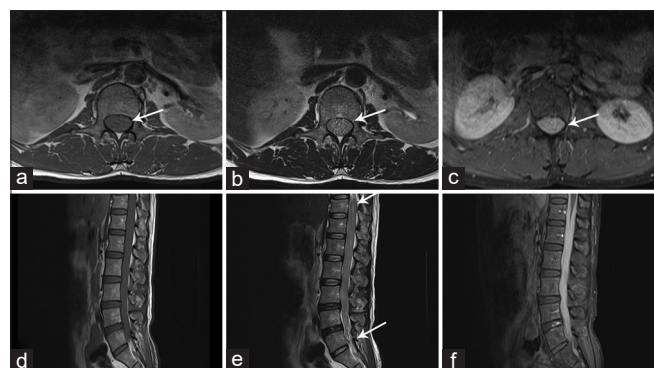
(a) Preoperative magnetic resonance imaging precontrast T1 axial, (b) T2 axial, (c) T1 postcontrast axial images, (d) Precontrast T1 sagittal, (e) T2 sagittal, (f) T1 postcontrast sagittal images. Nerve roots in the cauda equina show diffuse thickening with obliteration of intervening cerebrospinal fluid signal in T2-weighted images which appears isointense on T1-weighted image. Diffuse homogenous enhancement noted within the theca encircling the distal cord and conus and involving nerve roots
